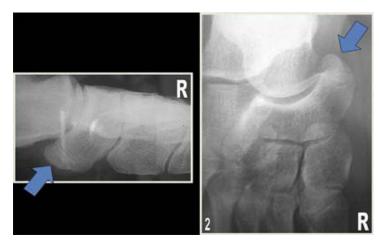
On the lateral and medial oblique radiographs, the additional ossific density is more readily seen lying medial and slightly proximal to the navicular (arrows), with evidence of a well corticated surface apposing that of the parent navicular.
